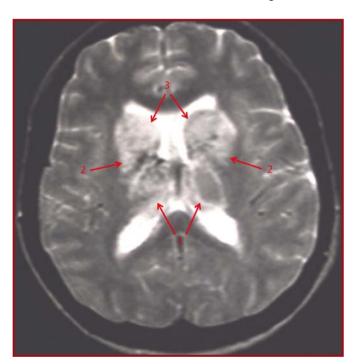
T2-weighted magnetic resonance imaging revealed hyperintense signals in the both thalami (1), anterior half of lentiform nuclei (2), in the caput and corpus of caudate nuclei bilaterally (3)
